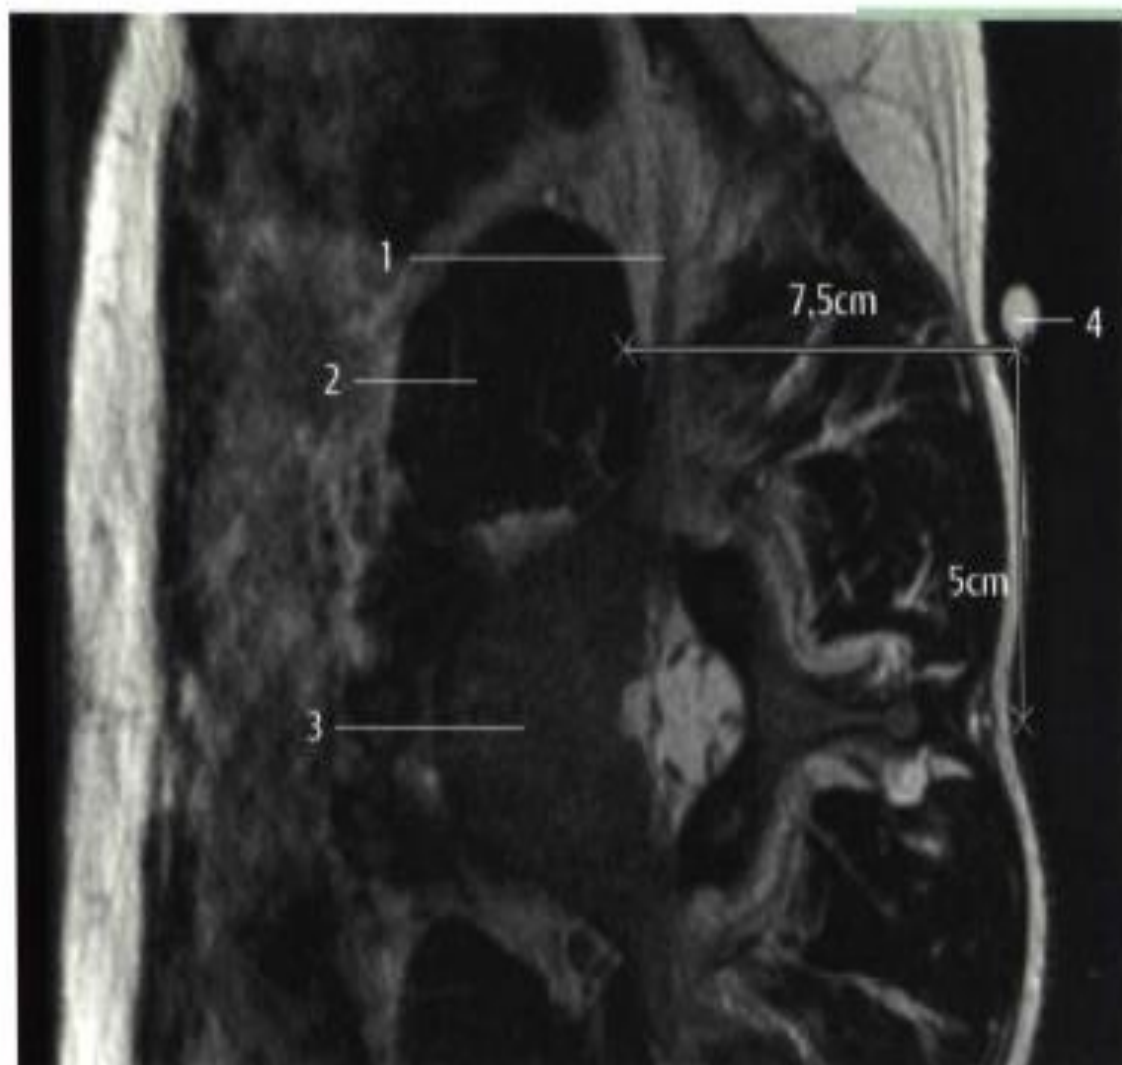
MRI scan at the level of the injection site for psoas compartment block. Note the depth of 7.5 cm at which the psoas major muscle is reached (average male, 75 kg, 185 cm).
